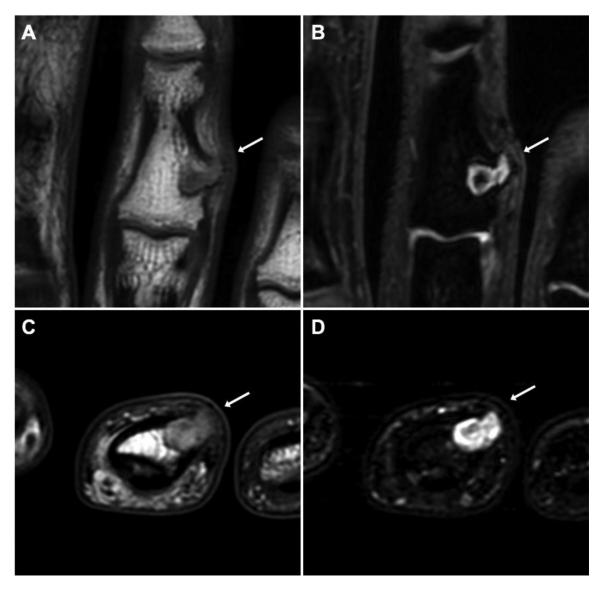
Goronal (A) and axial (C) T1-weighted and coronal (B) and axial (D) fluid sensitive MRI images of the left third finger reveal an expansile cortical-based lesion within the proximal metadiaphysis of the medial third middle phalanx (arrows), which demonstrate high T2 signal with internal foci with low to intermediate signal suggestive of internal chondroid matrix. The lesion extends through the cortex into the soft tissues.
